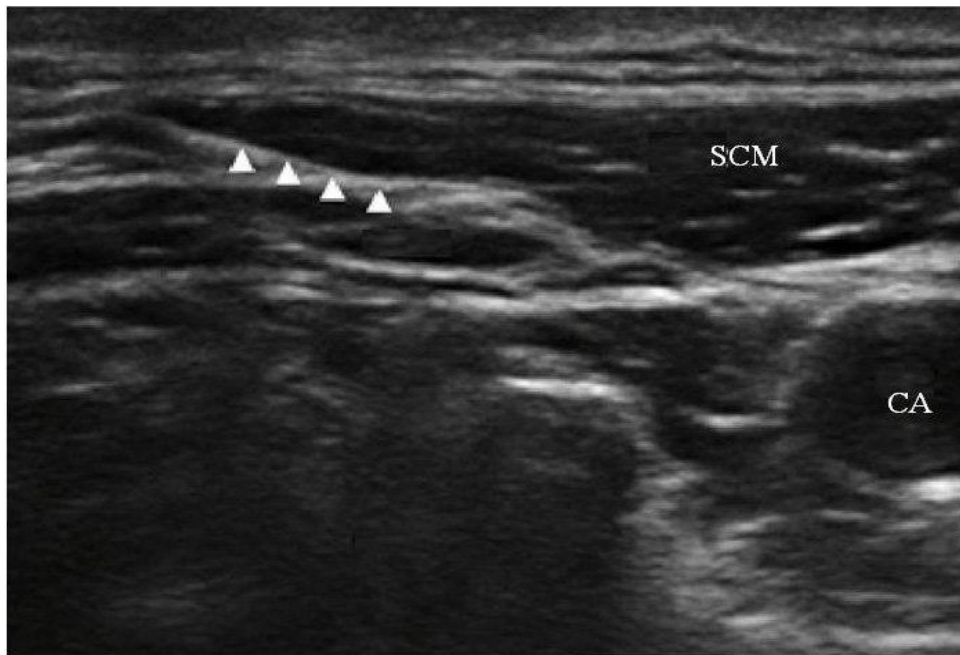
Ultrasound approach view of Superficial CPB (Herring, et al., 2012).
